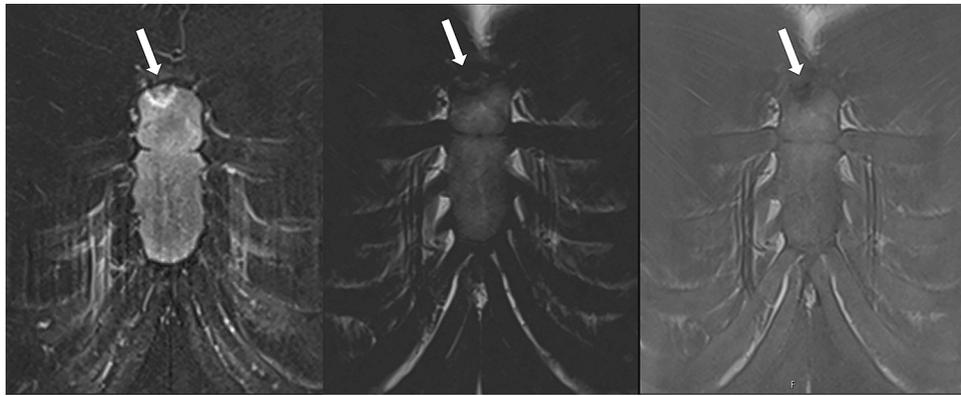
17-year-old adolescent with a) an area of irregularly increased signal on T2 Dixon water-only on the manubrium of the sternum (arrow) and corresponding low signal on both b) T2 Dixon fat-only (arrow) and c) T1-weighted image (arrow). The signal on the T1-weighted image is even lower than skeletal muscle.
